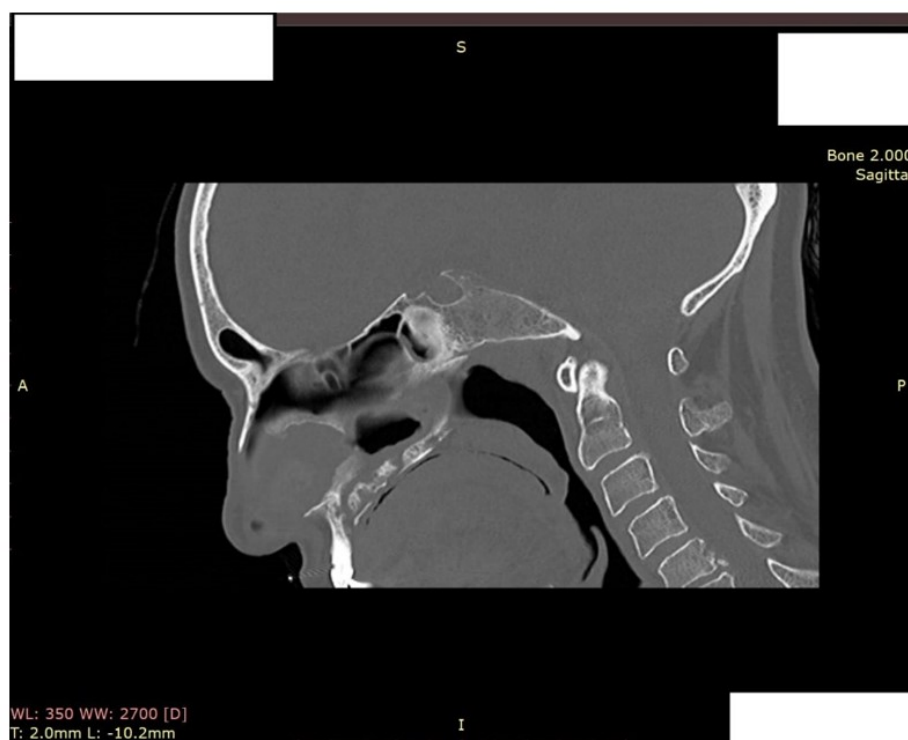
Sagittal CT paranasal sinus bone-window image demonstrating more conspicuous palatal destruction with communication toward the oral cavity, consistent with an oronasal defect.
